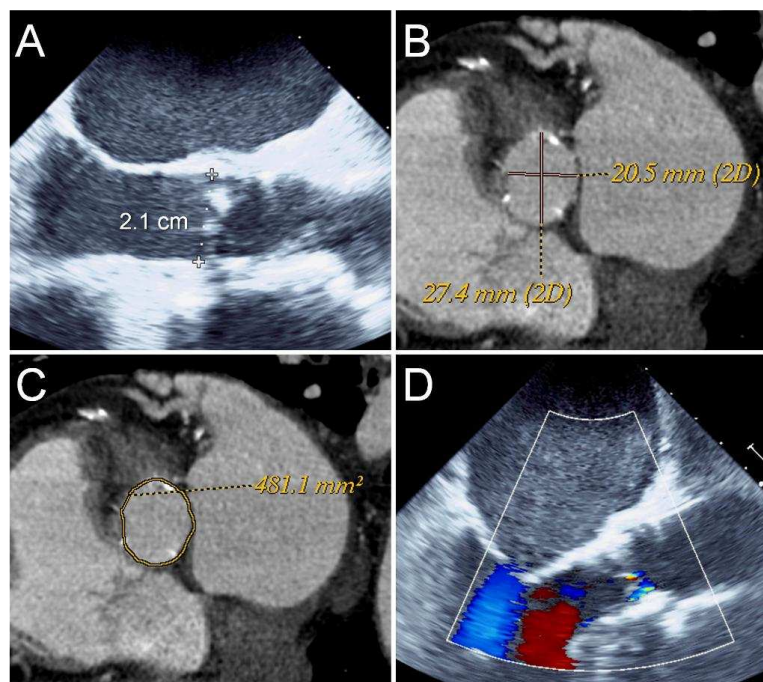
In a 79 year old patient TEE measured an annulus of 2.1 cm suggesting a 23 mm Edwards SAPIEN or a 26 mm Medtronic CoreValve (A). CT angiography measured an area of 481 mm² (C) and a mean diameter of 24 mm (B) suggesting a 26 mm Edwards SAPIEN or a 29 mm Medtronic CoreValve valve with ~10% oversizing. A 26 mm Edwards SAPIEN valve was implanted with trace paravalvular leak (D).
